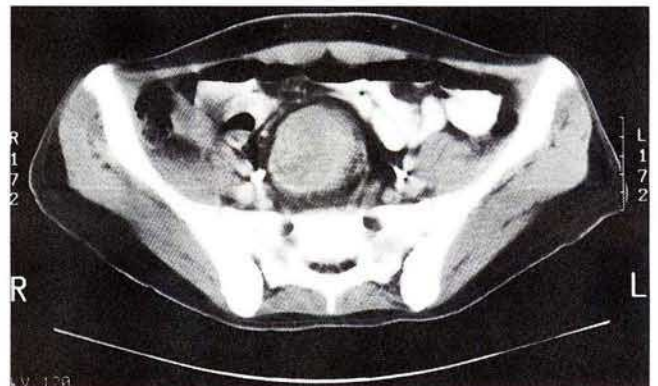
CT scan of pelvis showing a large heterogenous mass in the rectosigmoid region almost obstructing the bowel lumen.
